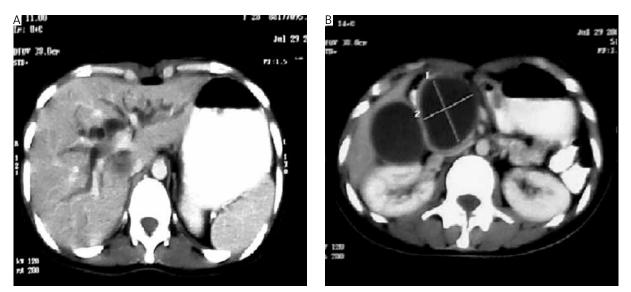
Abdominal CT scan: cystic lesion in distal part of CBD with biliary dilatation
